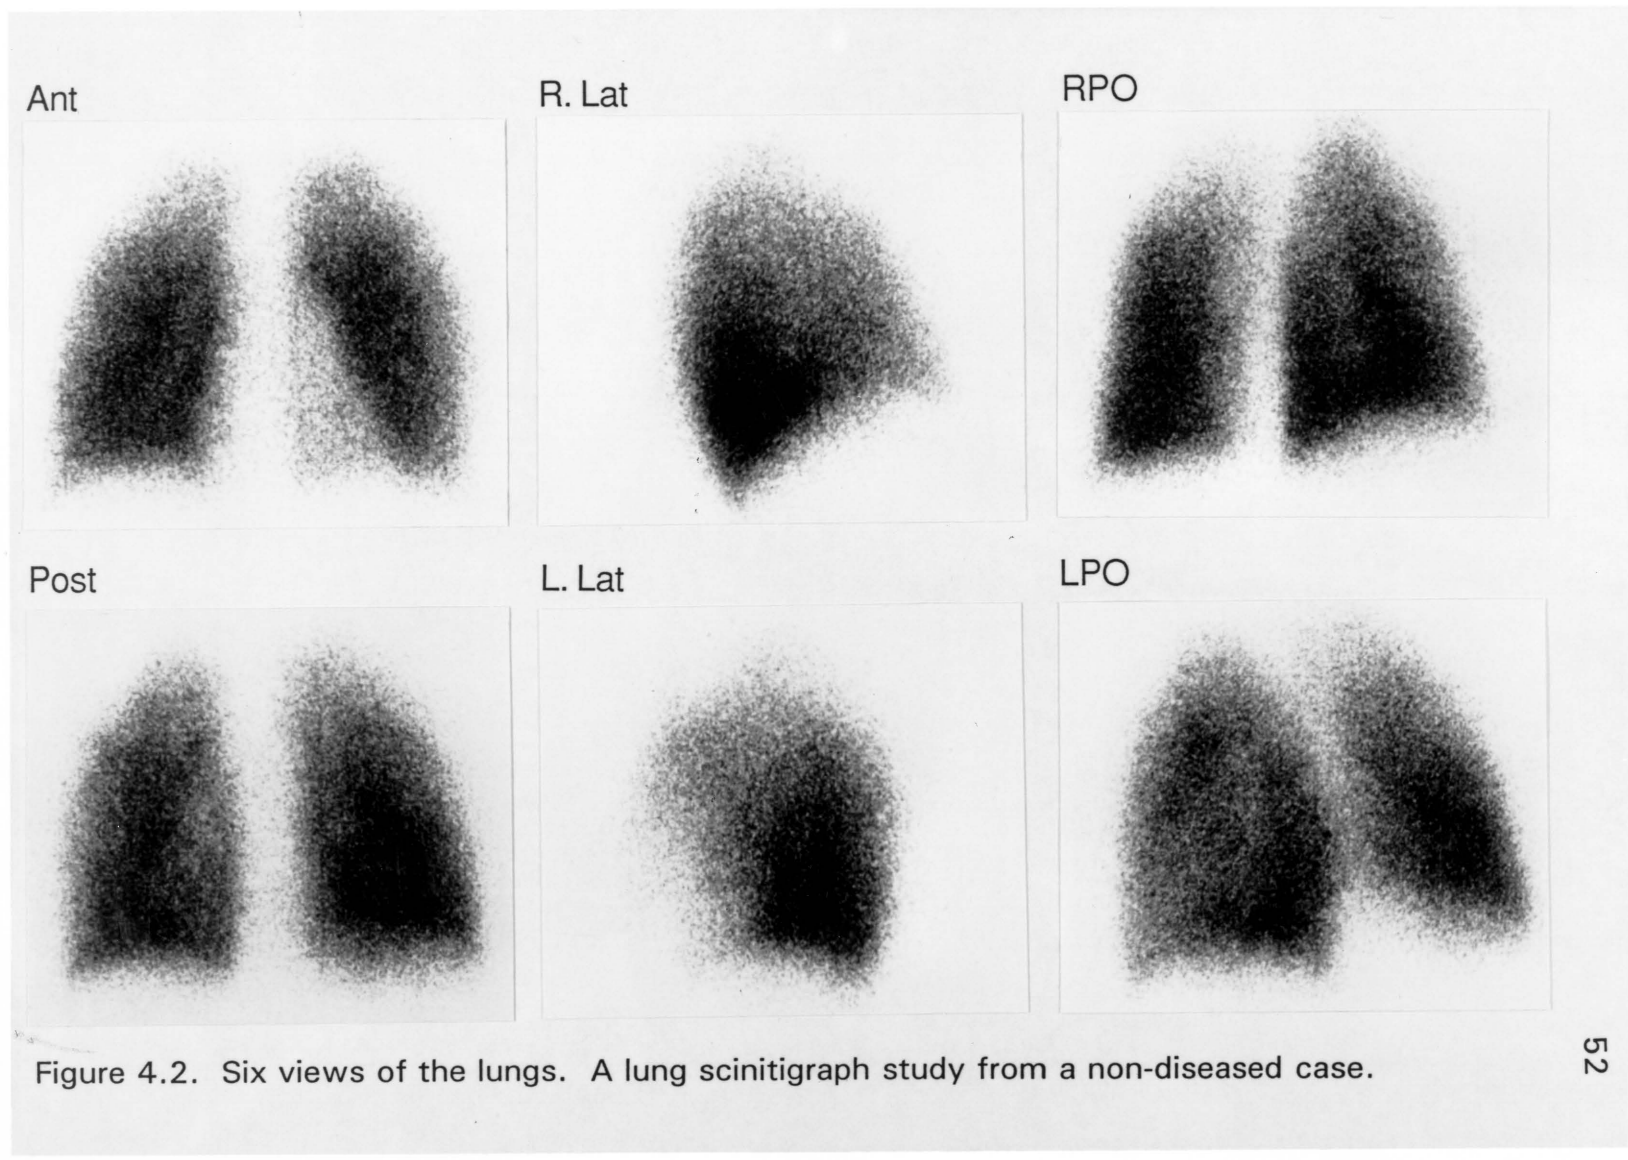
Six views of the lungs. A lung scintigraph study from a non-diseased case.
